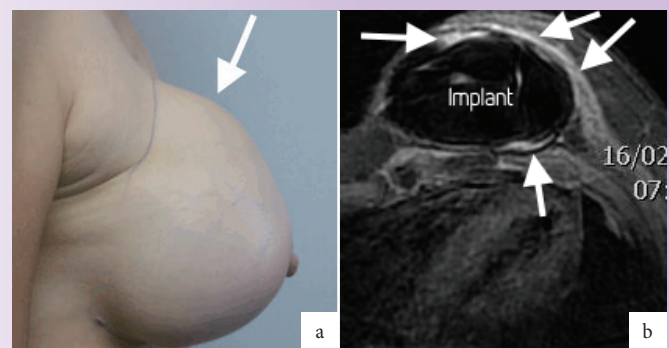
a. High-riding implant (arrow) is a feature of capsular contracture; pain, hardness and immobility represent other common clinical features. b. Silicone and fat-suppressed contrast-enhanced MR image showing a misshapen implant (globular) and an enhancing thickened fibrous capsule (arrows).
